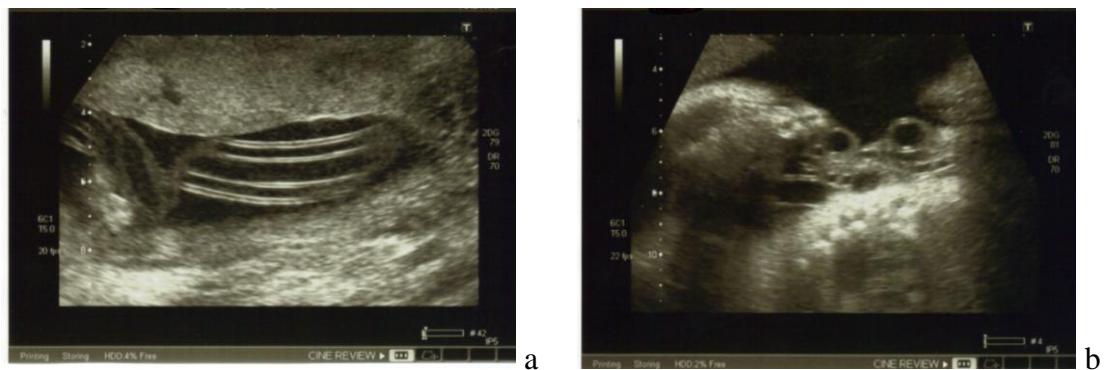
Antenatal ultrasound of cord coiling in (a) 2nd and (b) 3rd trimester of the same patient
